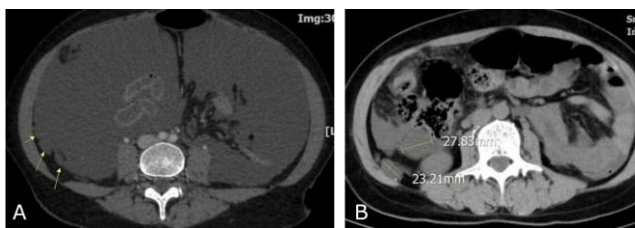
CT scanner of the patient before (A) and after treatment (B) showed a significant decrease of abdominal fluid; Some lymphatic aneurysms (arrow) before and after the intervention still endure, but there is no complication recognised, no further interventions have been indicated
